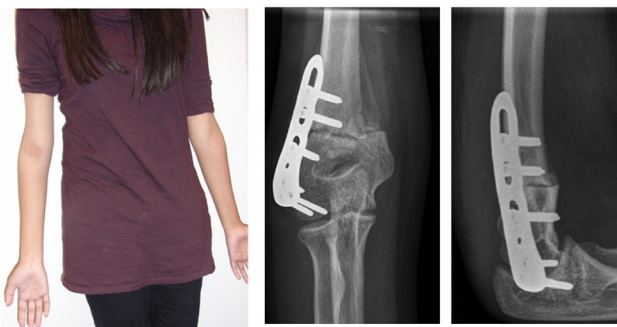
Cubitus Varus preoperative planning and correction. A: Preoperative Clinical Photo and Radiographs.
